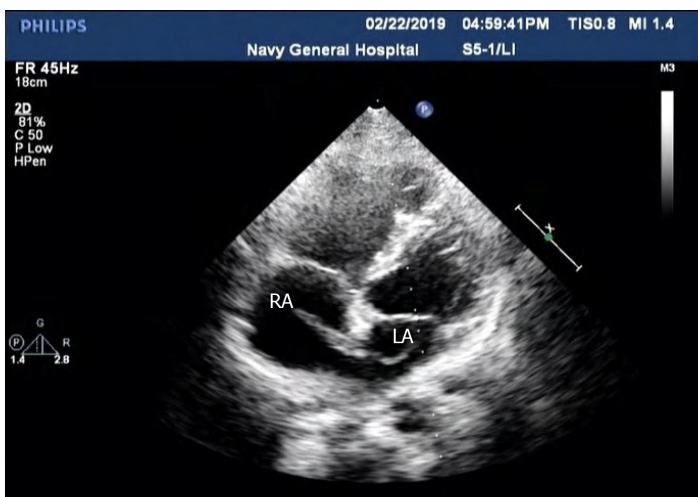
Transthoracic echocardiography showed a mass thrombus straddling a patent foramen ovale (3 mm × 20 mm in the left atrium, 8 mm × 25 mm in the right atrium). RA: Right atrium; LA: Left atrium.
